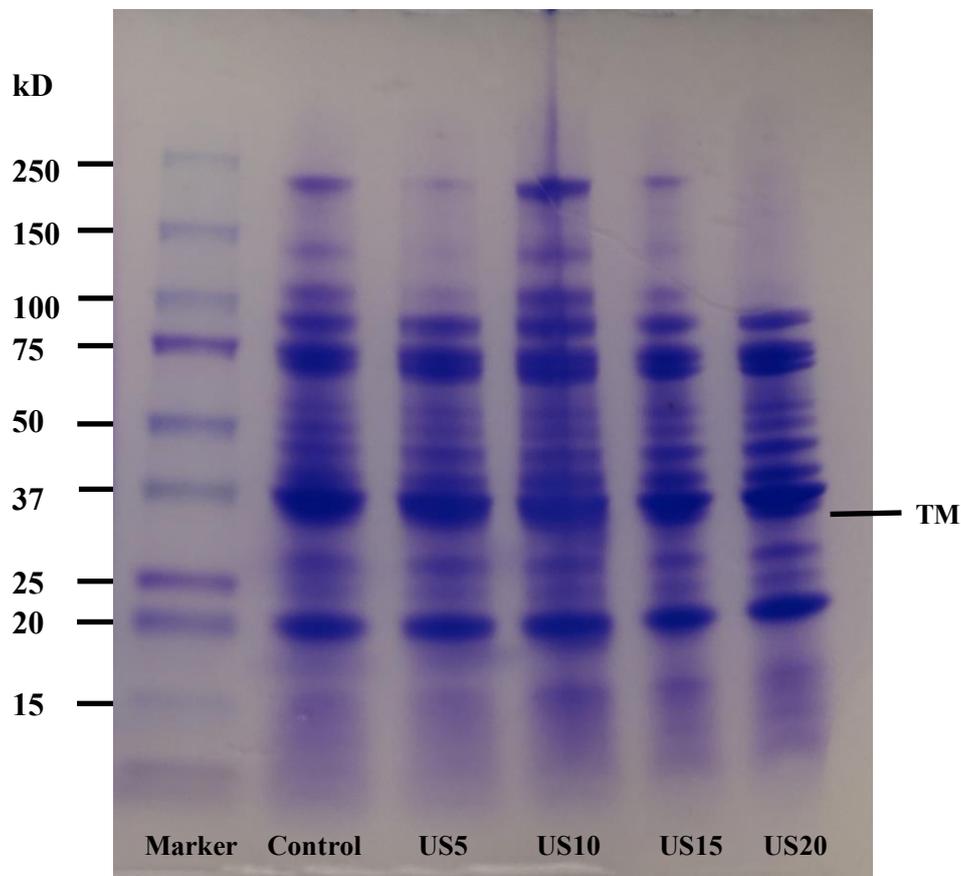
SDS-PAGE of ultrasound-treated and untreated proteins in shrimp sample
